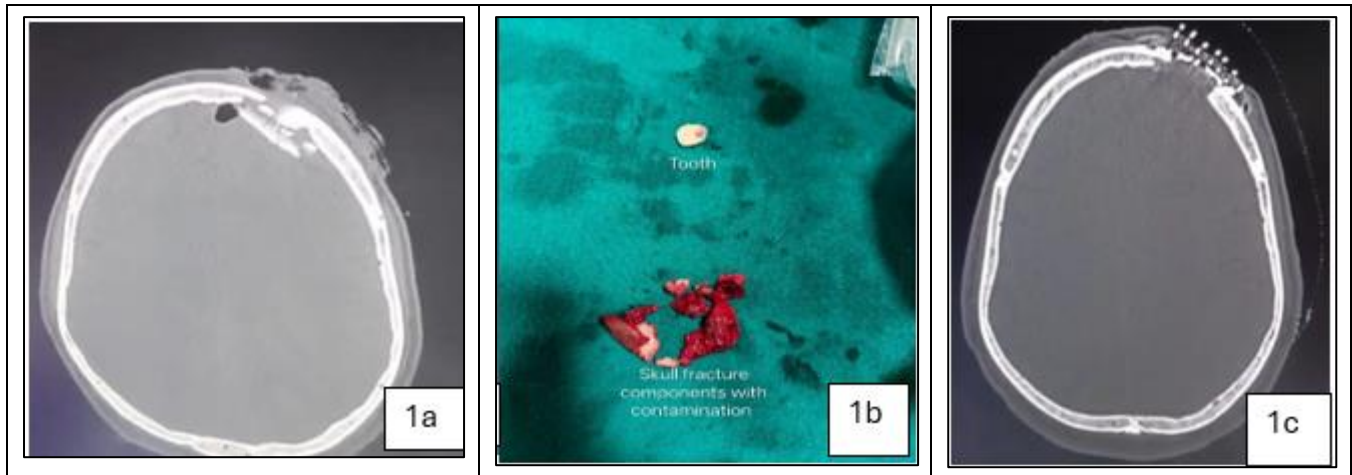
a Pre operative CT head bone window showed left frontal depressed compound fracture with epidural pneumocephalus and soft tissue changes. Fig 1 b Debride skull fracture components and tooth. Fig 1 c Post Operative CT head bone window showed left frontal well defined calvarial defect closed with titanium mesh without any remnant fracture components
